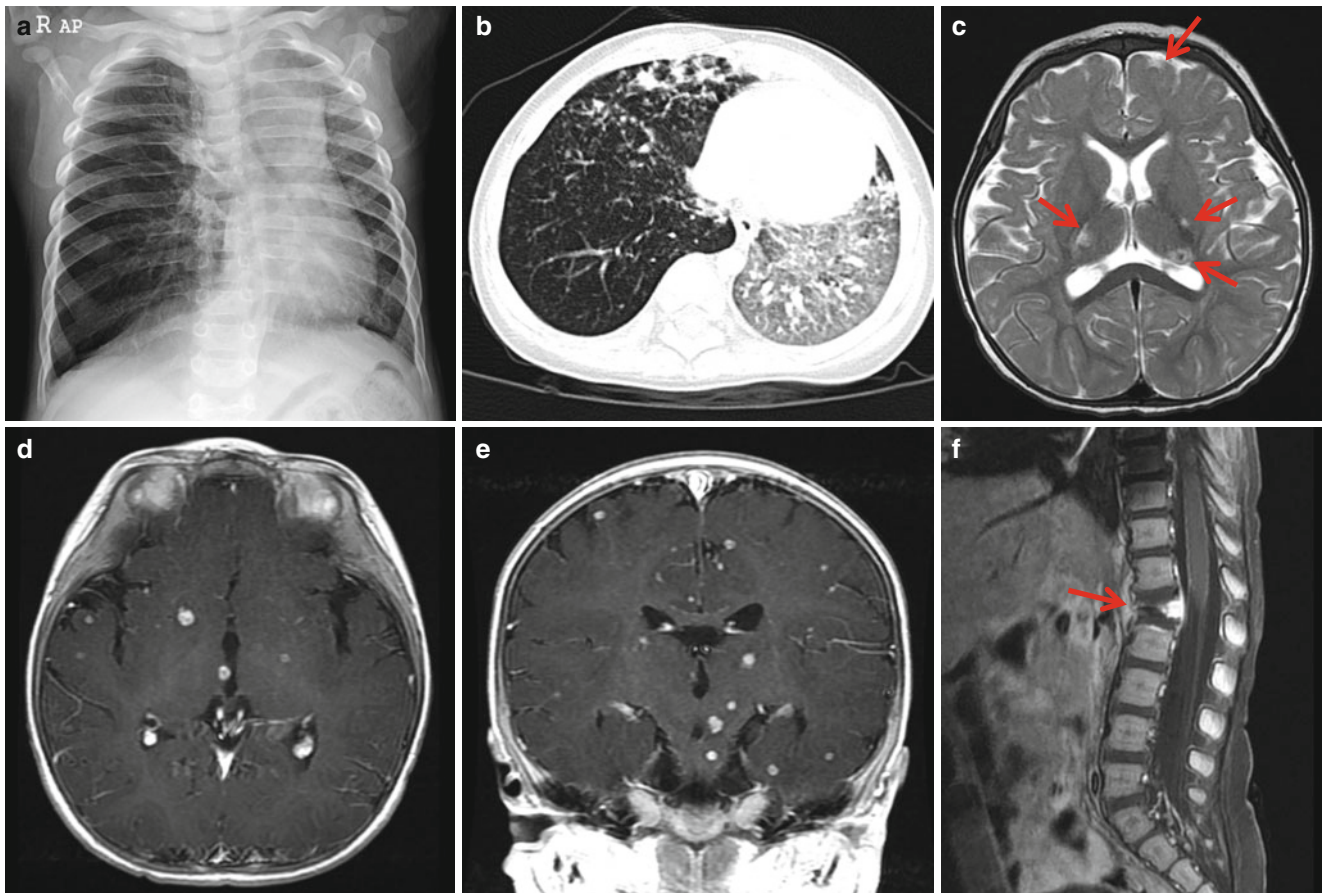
Disseminated tuberculomas are in the brain and spine of a 9-month-old boy. (a) Plain chest radiograph shows decreased left lung volume with subtle fine nodules in the left lung. Right lung shows hyperaeration and focal atelectasis in the suprahilar area. (b) Miliary nodules and bronchopneumonic infiltrations are well demonstrated with CT. The left lung is hyperaerated. (c) T2-weighted image shows
